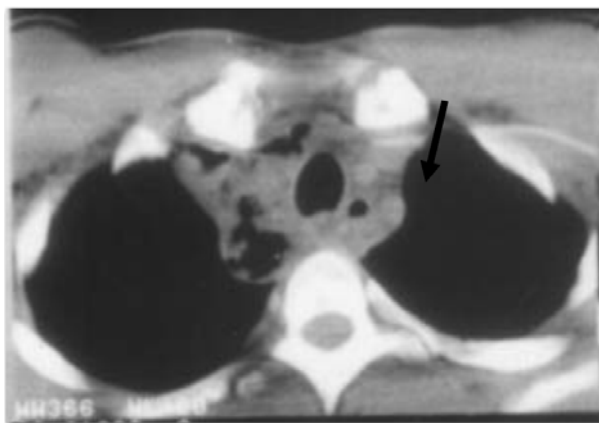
The CT revealing the mediastinum septic determinations
